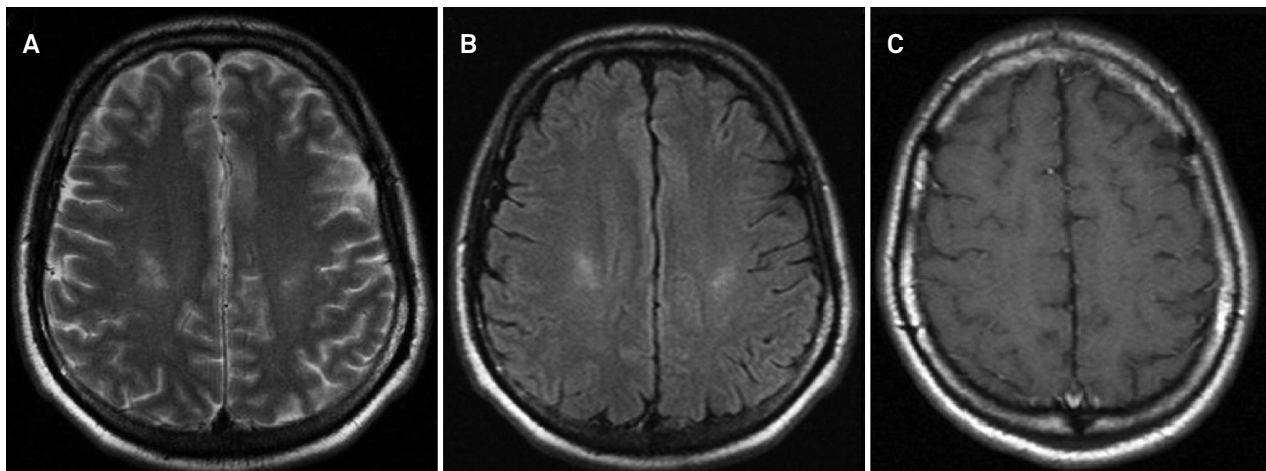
(A) Axial T2-weighted and (B) axial FLAIR-weighted brain MRI disclosing multiple frontal hyperintense signal changes in corticospinal tracts projections, a similar pattern observed in motor neuron disease. (C) Axial MTC sequence is normal, and no contrast enhancement was observed.
